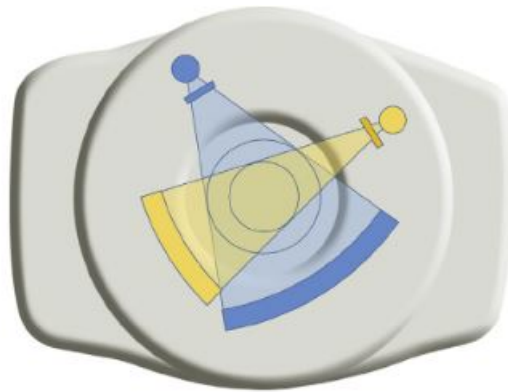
Dual source CT [18].
